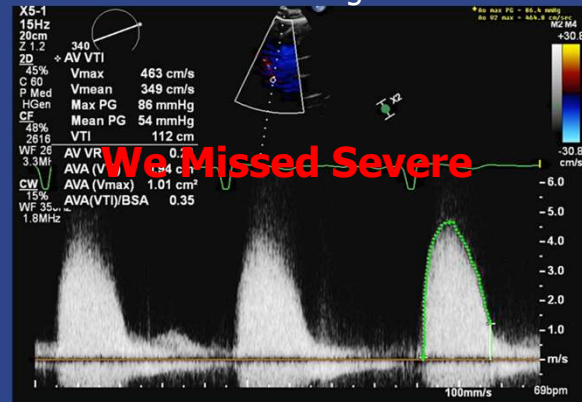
Right sternal boarder CW Doppler across surgical AV, UEA assisted, from author's clinical collection, di-identified (M.Trump, 2025)
